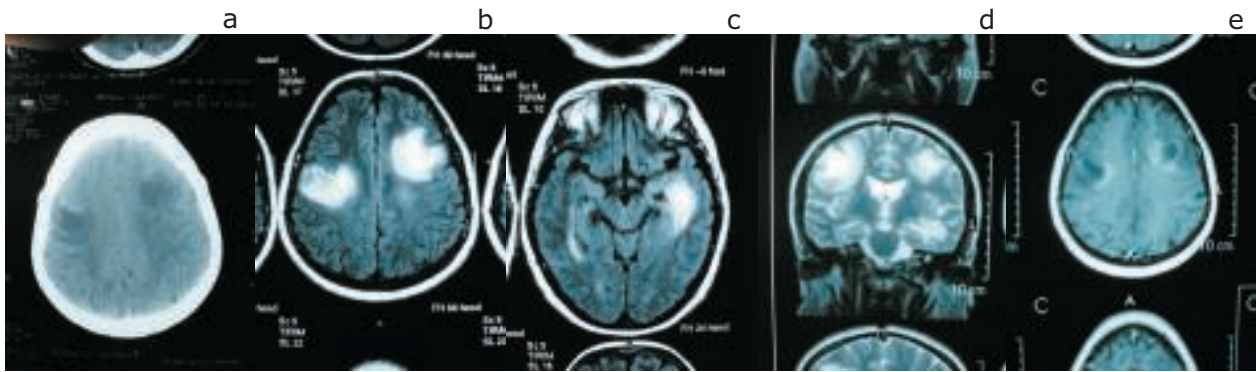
CT view before treatment (a), operation, T2 flair view (b), T2 flair view showing temporal lesion (c), T2 coronal view of the 3rd lesion in left temporal region (d) and contrast axial (e) view.
